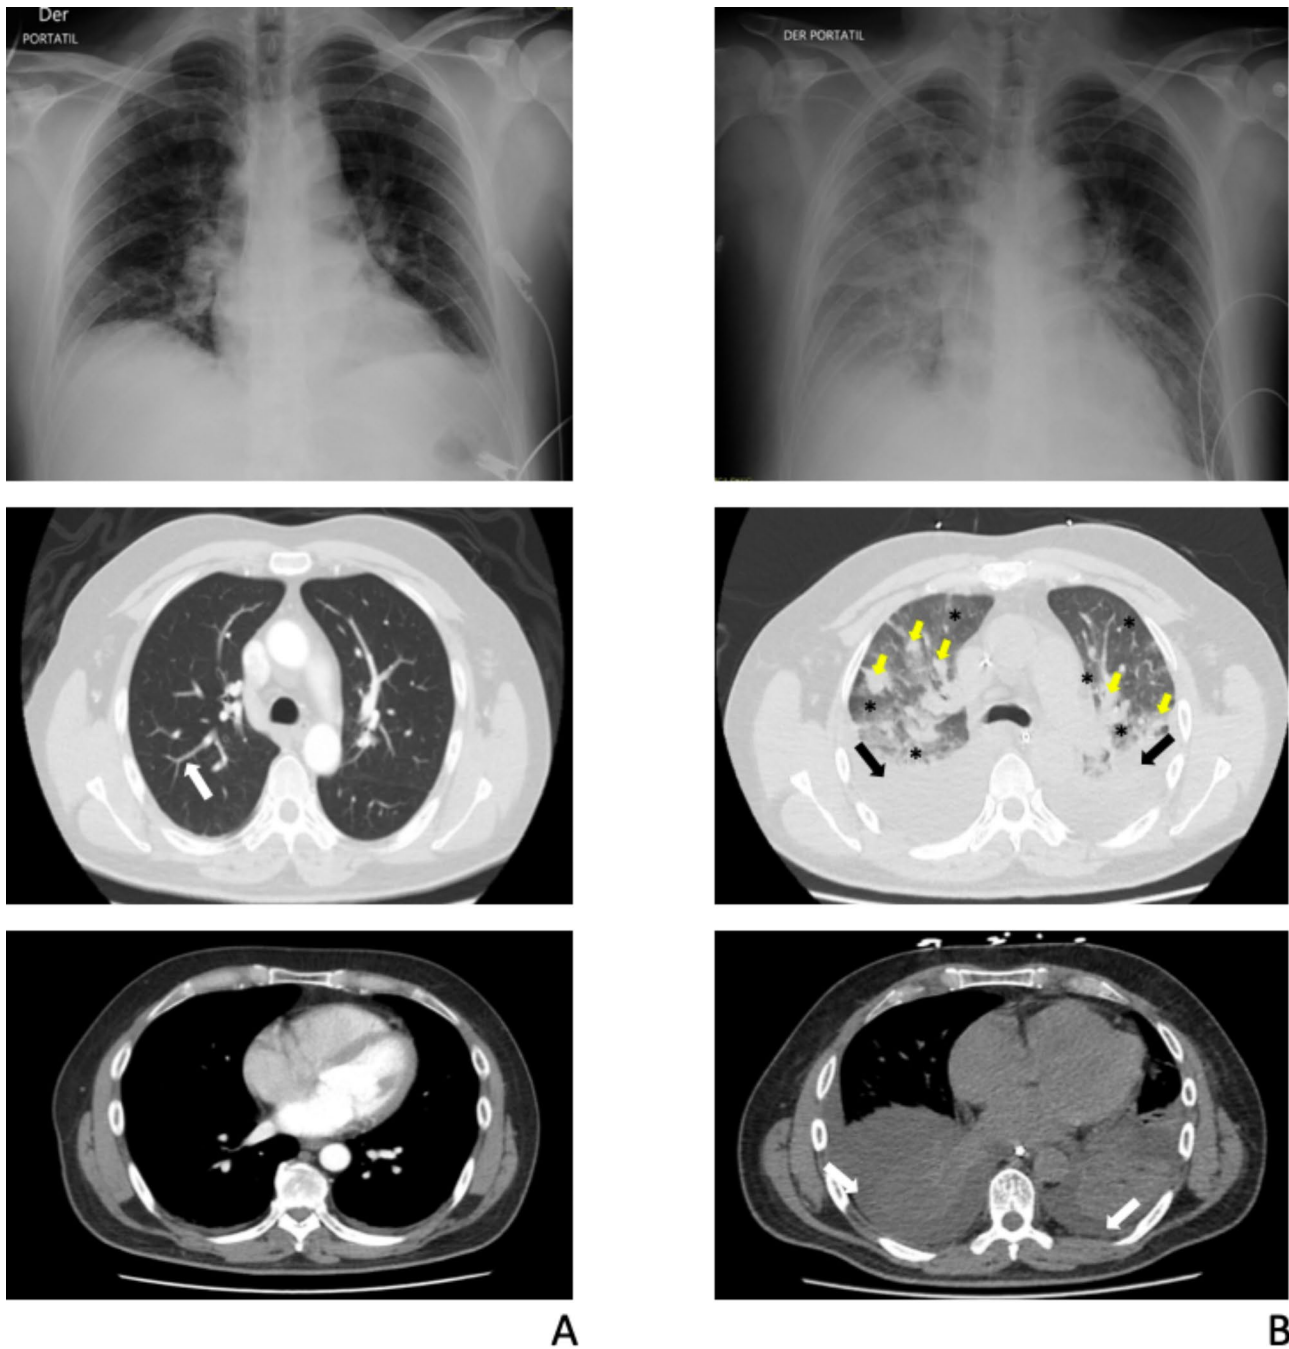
Chest X-rays and chest computed tomography (CT) scans. A Initial radiologic studies. Fibro atelectatic tracts compromising the posterior segments of bilateral inferior lobes (white arrow). B. Control radiologic studies (taken after respiratory deterioration). Bilateral basal consolidations involving all segments of the lower lobes (black arrows), associated with posterior pleural effusions (white arrows). Extensive patchy opacities in the periphery of both lung fields (yellow arrows). Ground glass pattern in the remaining lung fields (black asterisks)
